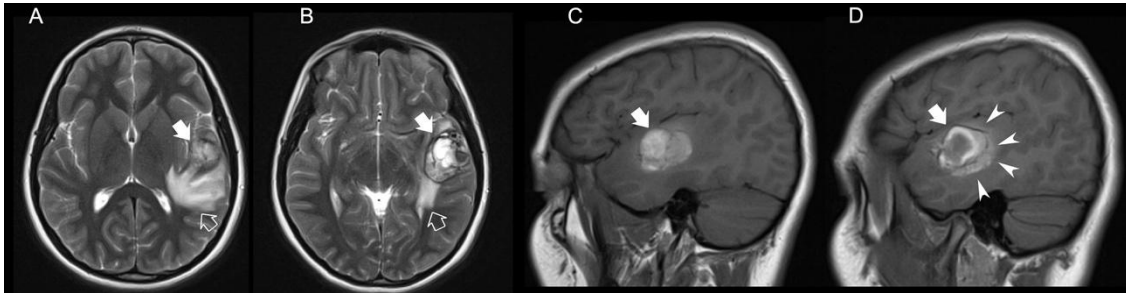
Brain MRI including axial T2WI (A,B) and sagittal T1WI (C,D) in a young girl presenting with an acute neurologic deficit reveals an intra-axial expansile mass located in the left temporo-opercular region with a hiper-isointense core in both pulse sequences (*thick white arrows*), in keeping with an acute hemorrhagic lesion. There are signs of perilesional edema (*open white arrows*) as well as moderate loco-regional mass effect. Also note presence of a hyperintense T1WI perilesional sign (*white arrowheads*), supporting the diagnosis of a cerebral cavernous malformation Zabramski type I.
